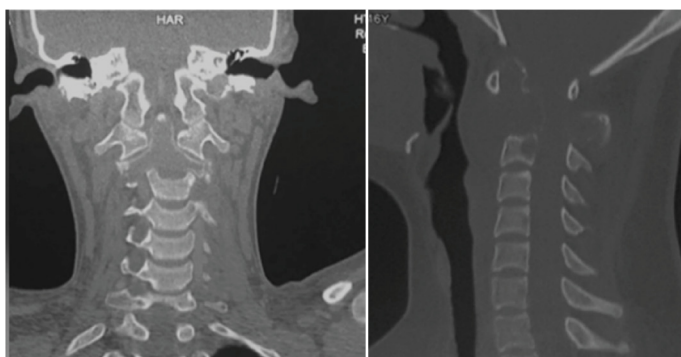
Cervical CT scan in a patient with C2 involvement showing instability in the coronal plane and laterolisthesis caused by the tumor lesion.
